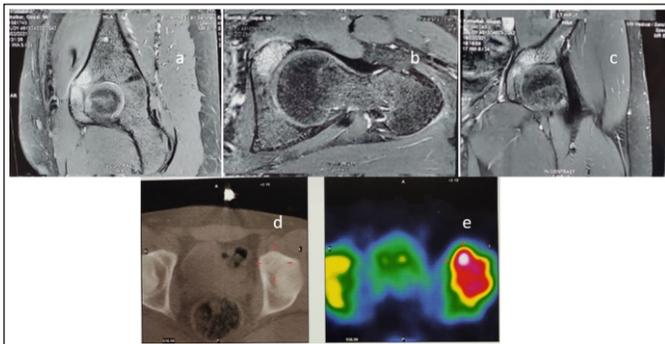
Combination of additional investigations like magnetic resonance imaging (a-c), computerized tomography (d), and nuclear bone scan (e) showing features of osteoid osteoma in anterior wall of acetabulum.
